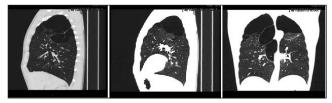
Chest computed tomography (sagittal and coronalview, lung soft tissue window) revealed bulla in upper lobe, in right side 10,8cm, and left side 10,9cm diameter
